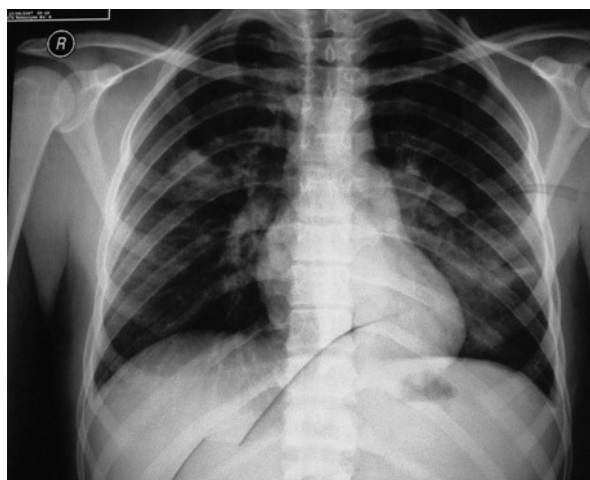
Bilateral infiltrates seen in Chest x-ray.
